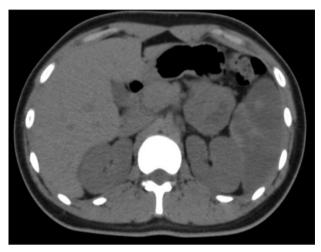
Abdominal computed tomography showed that spleen was enlargement, uneven density. Abundant hypodensity shadow was found. The infarction area was over 80% of whole spleen.
